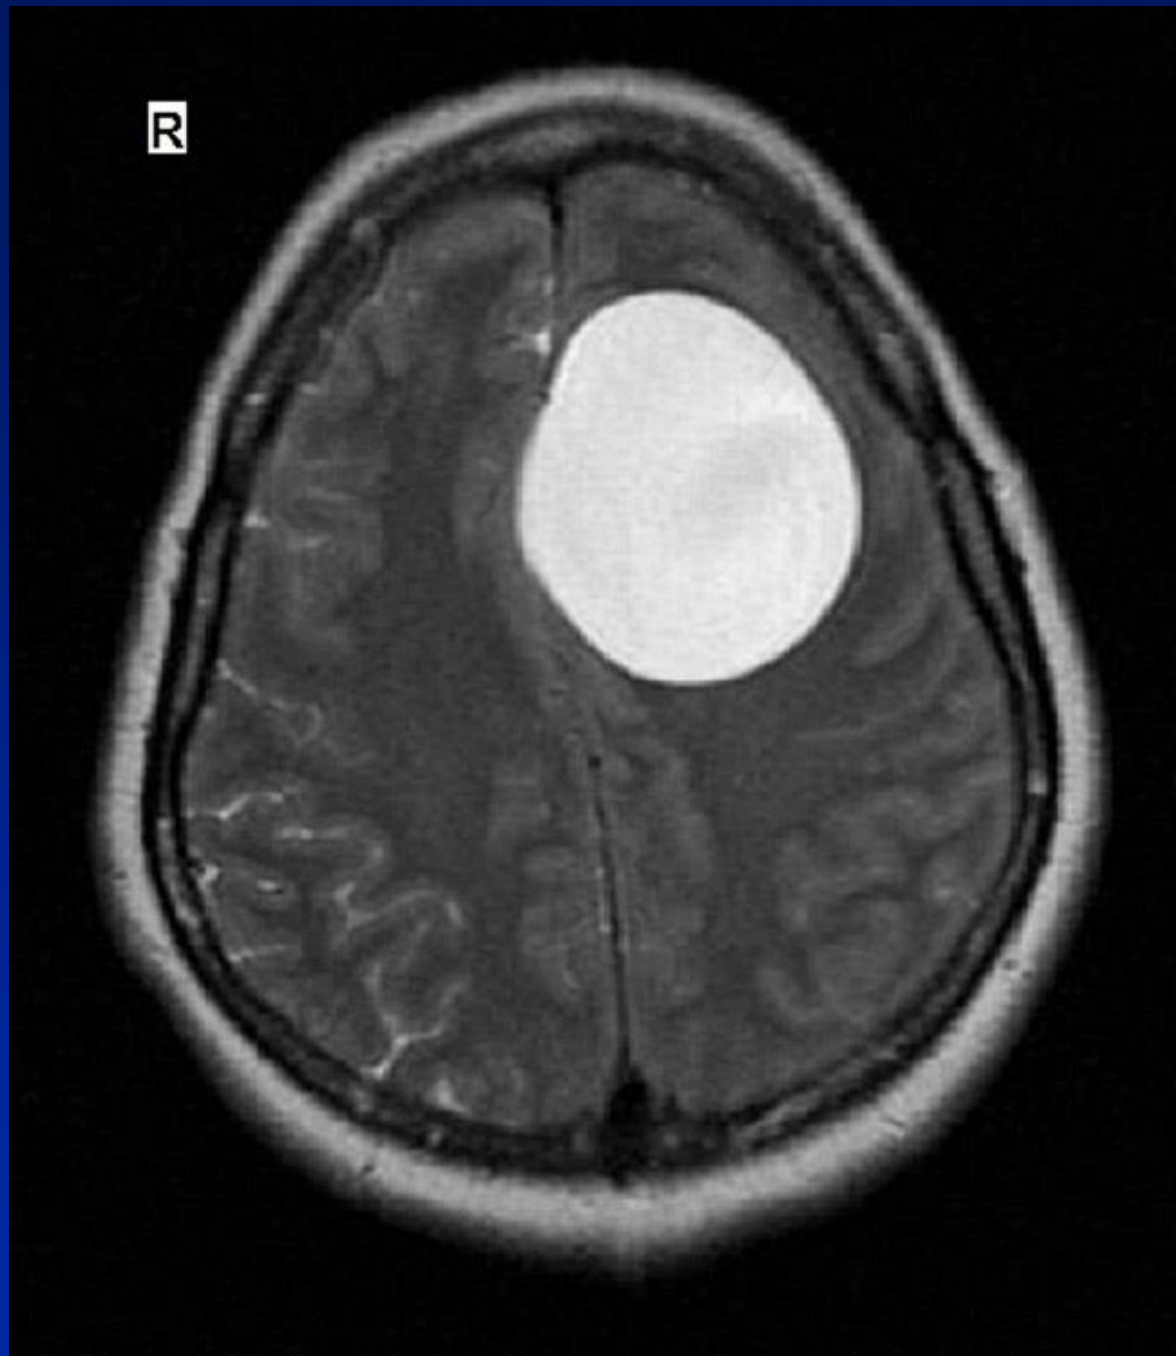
Axial T2-weighted MRI of the brain showing a large, well-circumscribed, hyperintense lesion in the right hemisphere.
